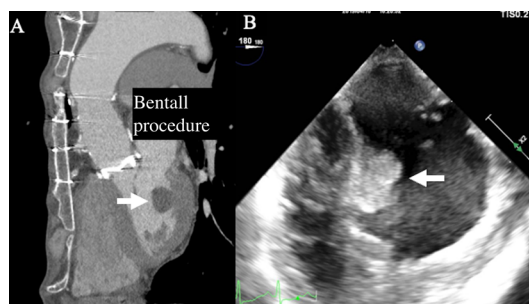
(A) Enhanced CT confirmed a mass (white arrow) located in the left ventricle. (B) Transthoracic echocardiographic findings confirmed a mass (white arrow) located in the left ventricle.
